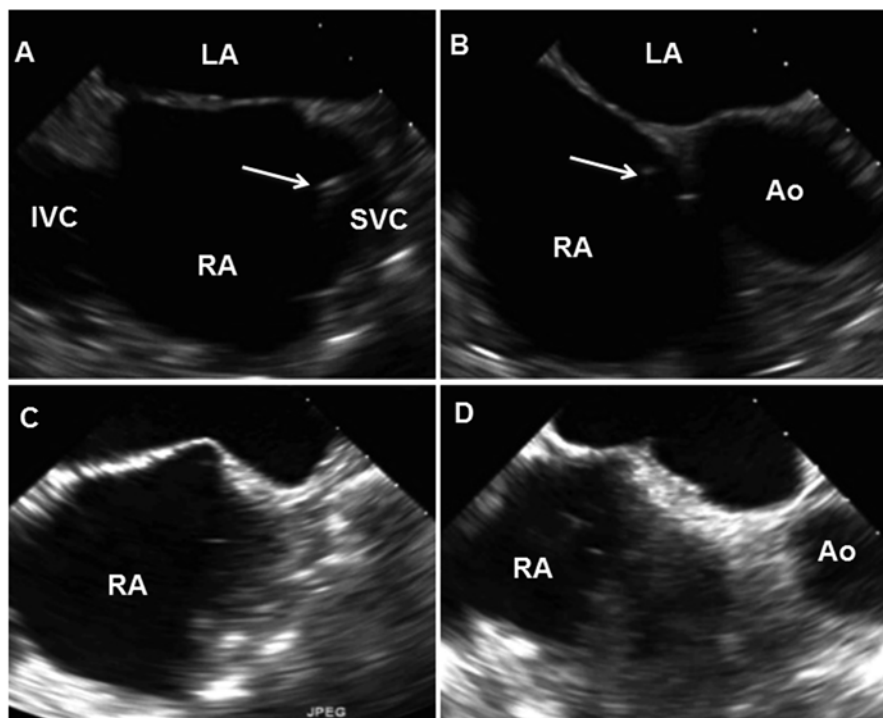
Transesophageal echocardiography for transseptal catheterization. Bicaval and short-axis views of the intra-atrial septum are useful for an inferior–posterior transseptal puncture. The bicaval views (panels a and c) allow for superior (closer to the SVC) to posterior (closer to the IVC) orientation, while the short-axis view allows for anterior (near the Ao) position. The *arrows* in panels (a) and (b) indicate the transseptal sheath in the SVC. Panels (c) and (d) demonstrate “tenting” of the transseptal needle on the foramen ovale. LA left atrium, RA right atrium, SVC superior vena cava, IVC inferior vena cava, Ao aorta (Reproduced from Koneru et al. [14] with permission)
